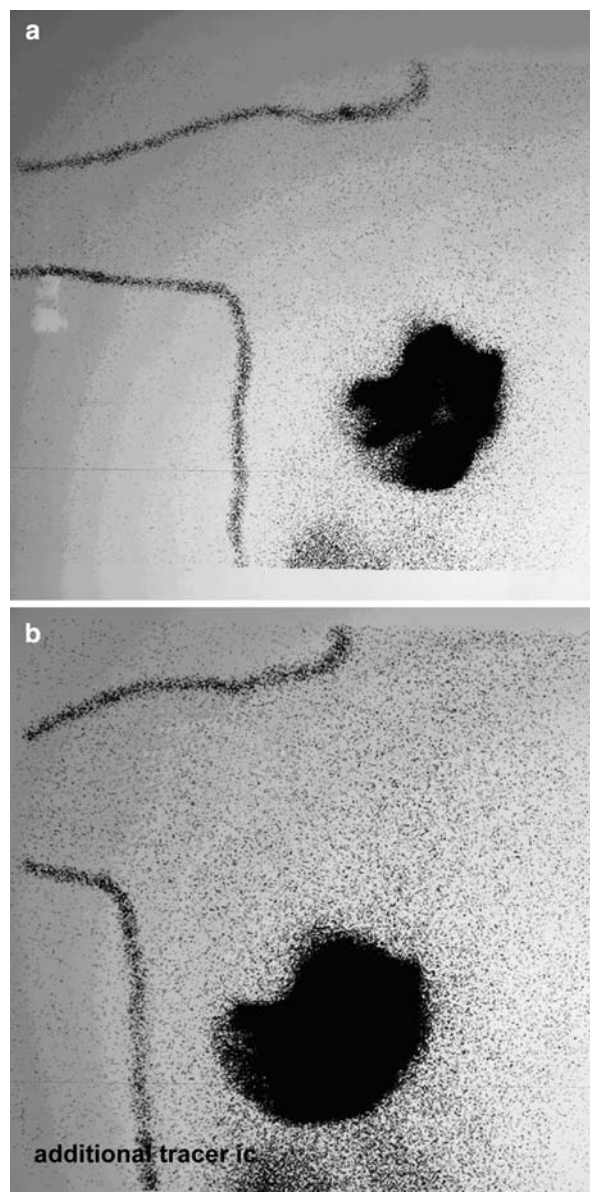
Lymphoscintigraphy of patient with initial scan failure (a) and secondary scan failure after additional tracer injection (b)
